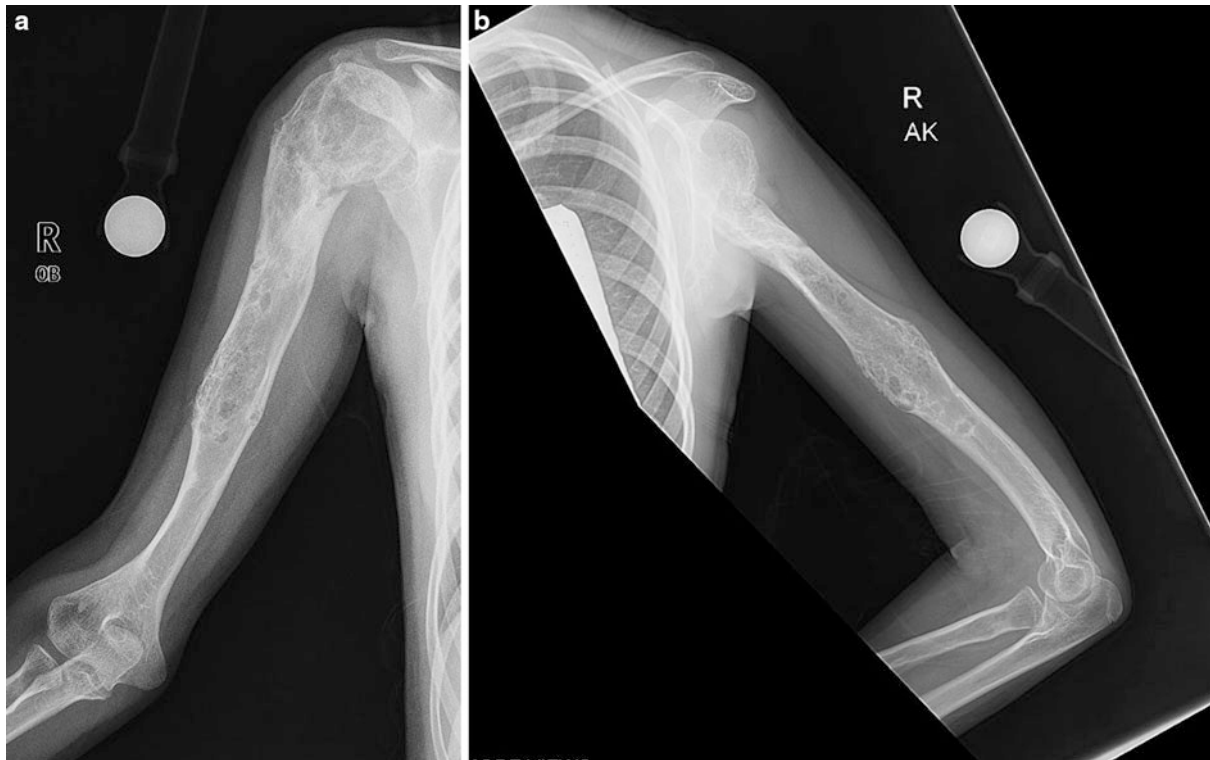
(a, b) Final AP/lateral X-rays after completion of a second lengthening and residual deformity correction done at age 15. Recurrent apex anterior deformity was corrected and 5 cm of additional lengthening was done
